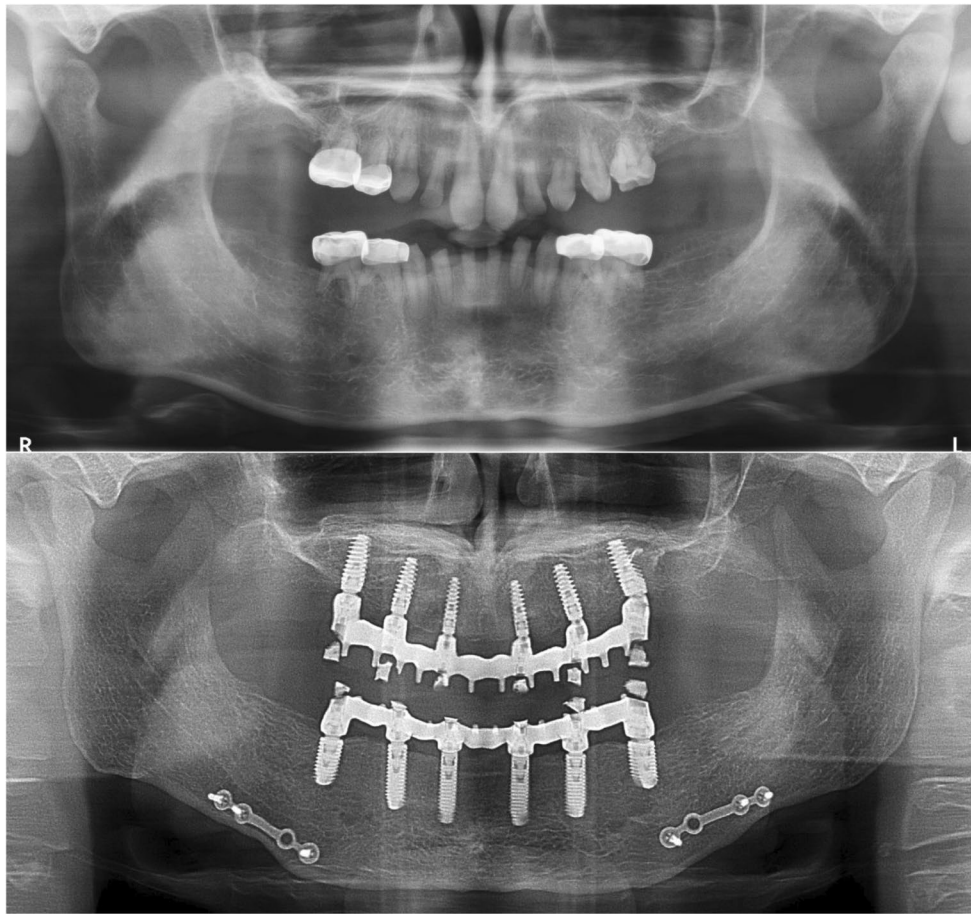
(A) Panoramic radiograph of a patient aged 15 years with 14 missing permanent teeth. (B) Panoramic radiograph at 18 years after maxillary bone grafting and mandibular sagittal osteotomy. (C) Control panoramic radiograph of a patient aged 30 years with 12-elements fixed implant-supported bridge and single-tooth prosthesis
